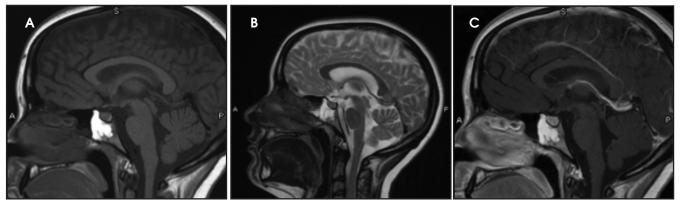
MRI sagittal images on the sphenoclival lesion. (A) T1-hyperintense, (B) T2-hyperintense, and (C) T1 postcontrast images demonstrate enhancement.
